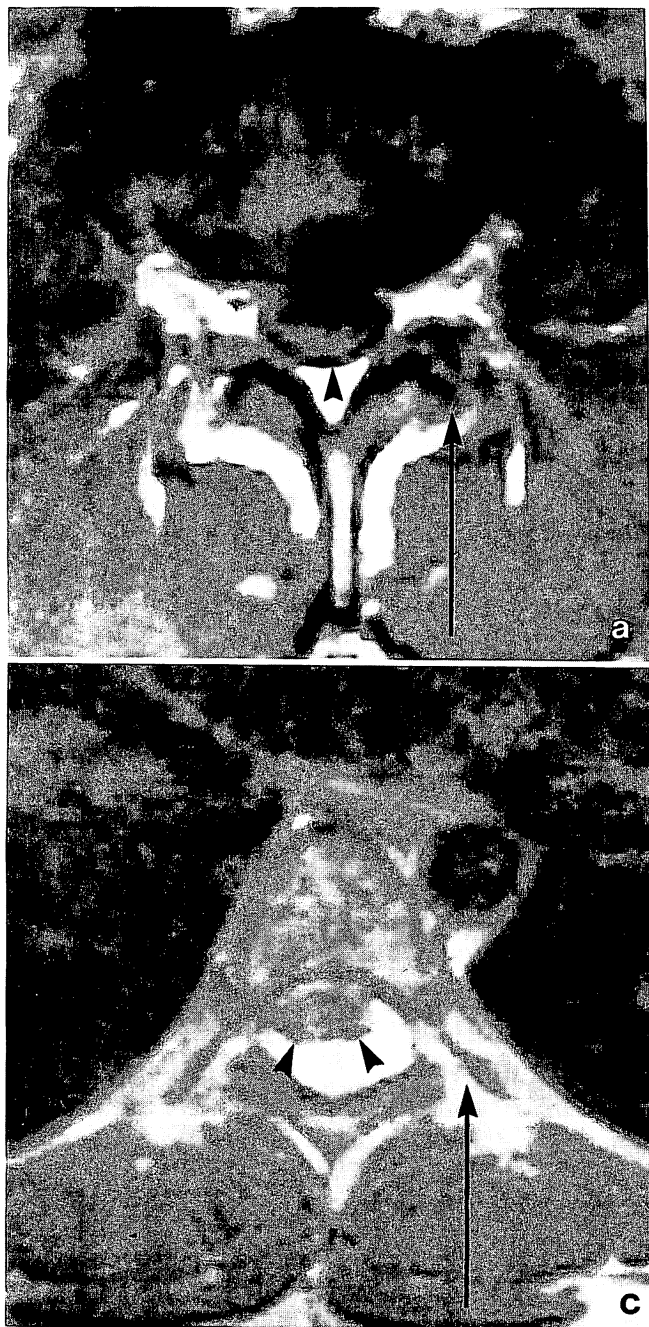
Chemical shift artifact. T1-weighted SE images. Arrows indicate direction of frequency-encoding (read-out) gradient. a) and b) Normal lumbar spine. Arrowheads indicate low intensity menisci attributable to chemical shifts of epidural fats. c) A 16-year-old male with lipoma. Surgery revealed that the lipoma was intradural and extramedullary and firmly attached to the spinal cord. Arrowheads indicate the chemical shift artifacts, which resemble a shadow of the dura mater
